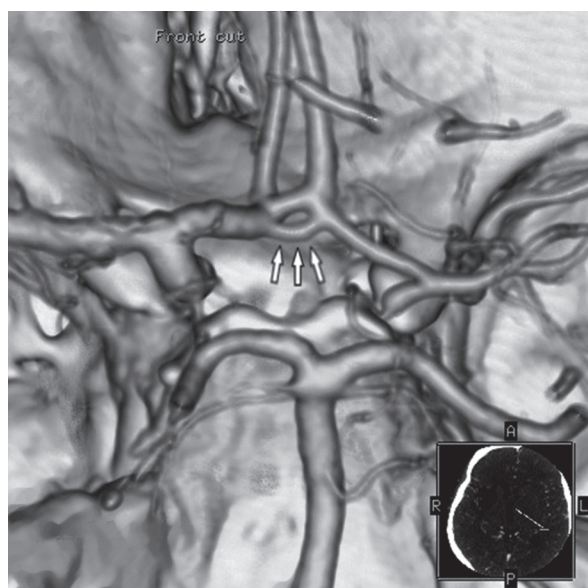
CT angiography – 3D volume rendering – anterior communicating artery fenestration (white arrows)
